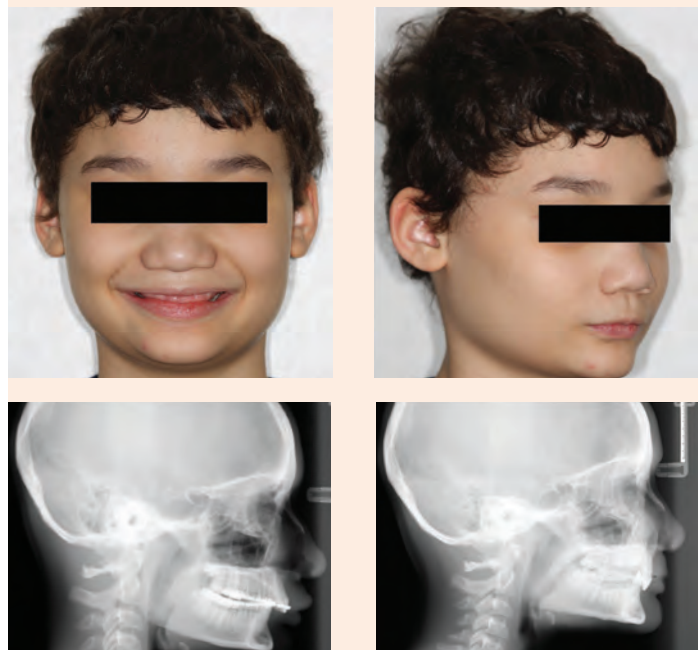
Pre-treatment records and pre-Herbst cephalometric radiograph for Case One.
